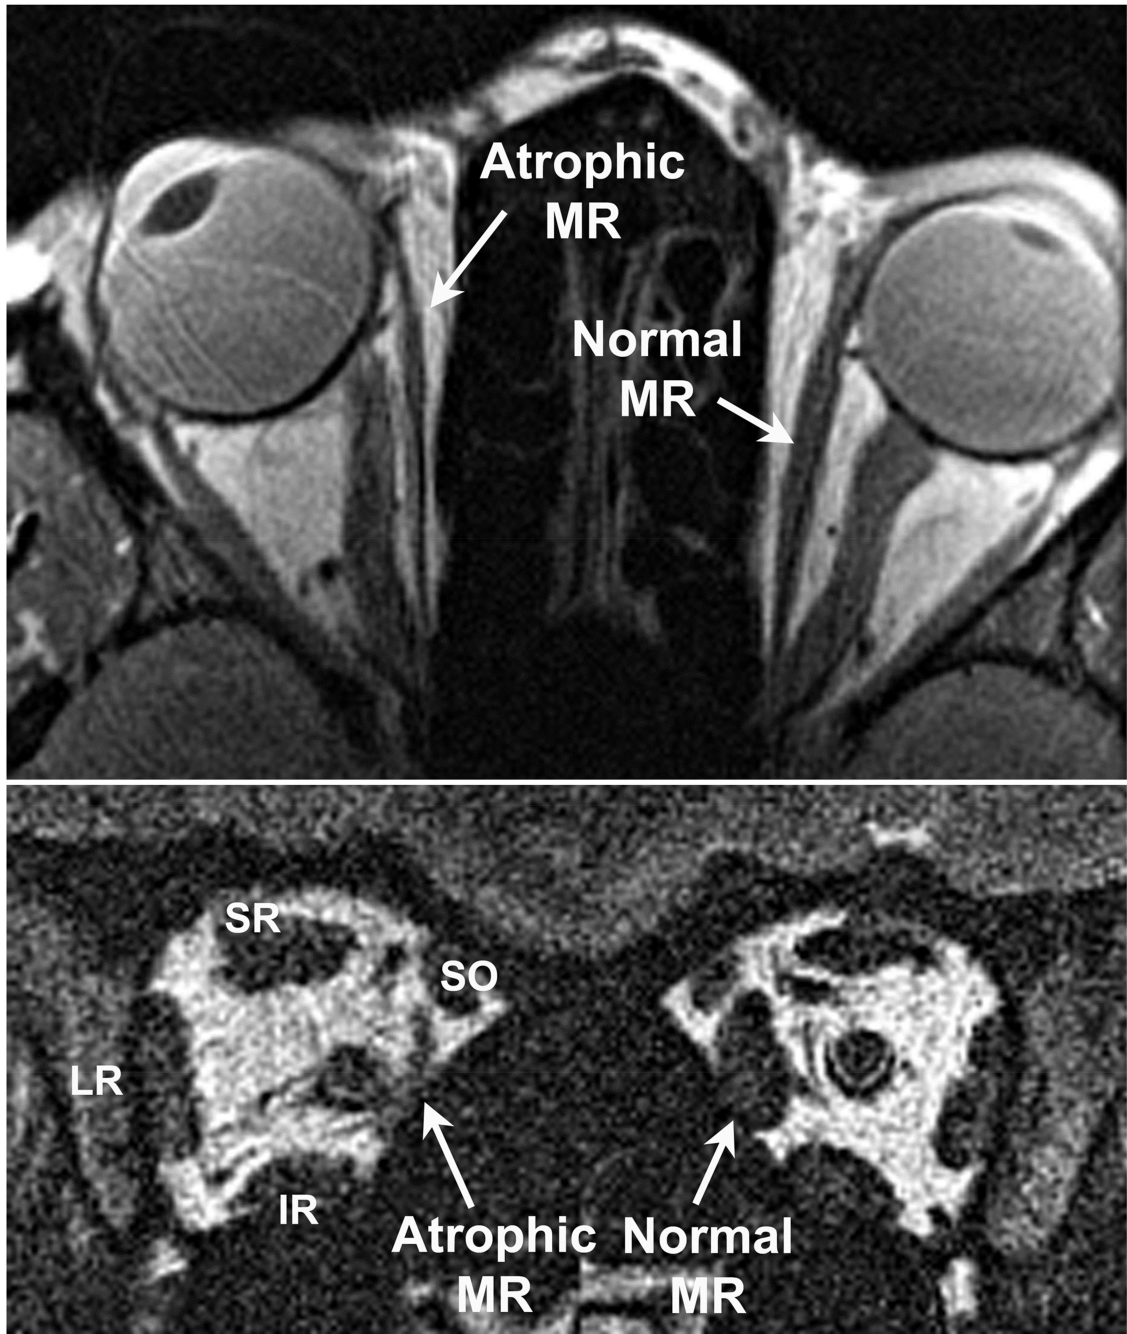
High-resolution surface coil MRI of the orbits of case 2 with right medial rectus motor nerve schwannoma demonstrating profound atrophy of the deep portion of the right medial rectus muscle (MR).
